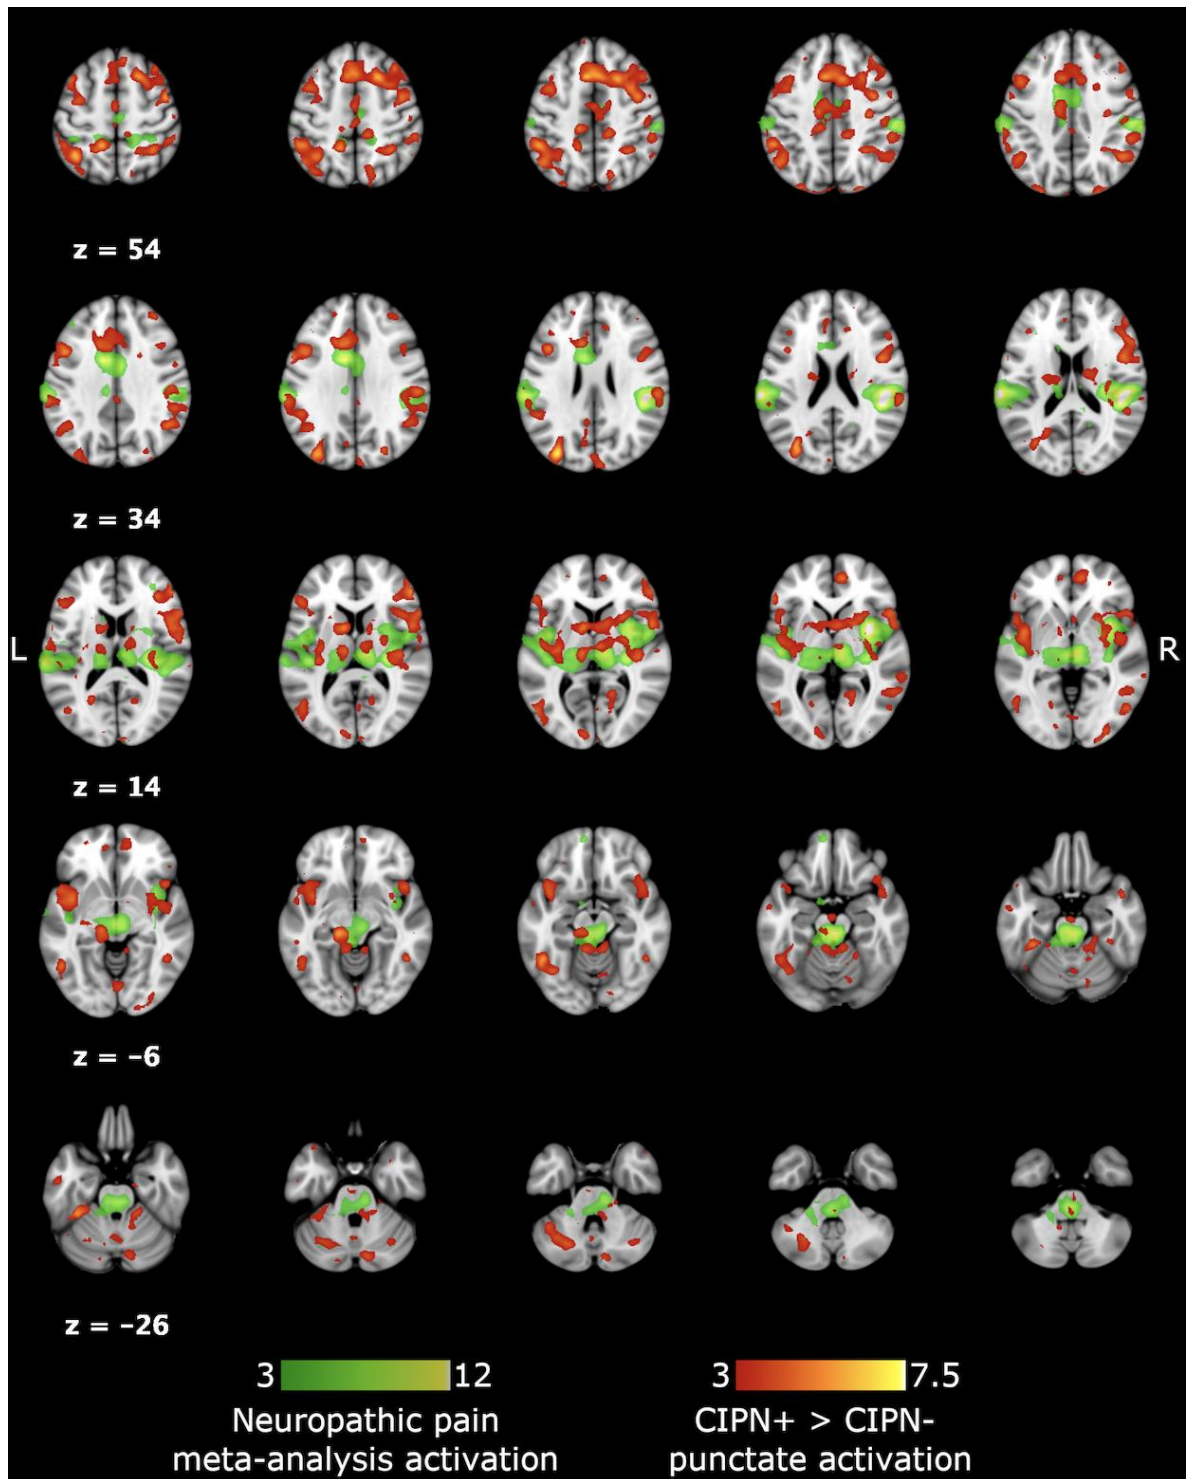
NeuroQuery meta-analysis derived z-score brain activation maps showing neuropathic pain study findings (in green) with CIPN+>CIPN- z-score brain activation maps, in response to punctate nociceptive stimuli, overlaid (in red). NeuroQuery is a toolbox that allows users to generate a predictive MRI-derived spatial distribution for any term, in our case neuropathic pain; based on very large-scale meta-analyses of functional MRI studies <https://neuroquery.org/query?text=neuropathic+pain>. It is again important to highlight that the red results occurred in pain free patients prior to CIPN development, while the green meta-analyses results show established neuropathic pain states.
